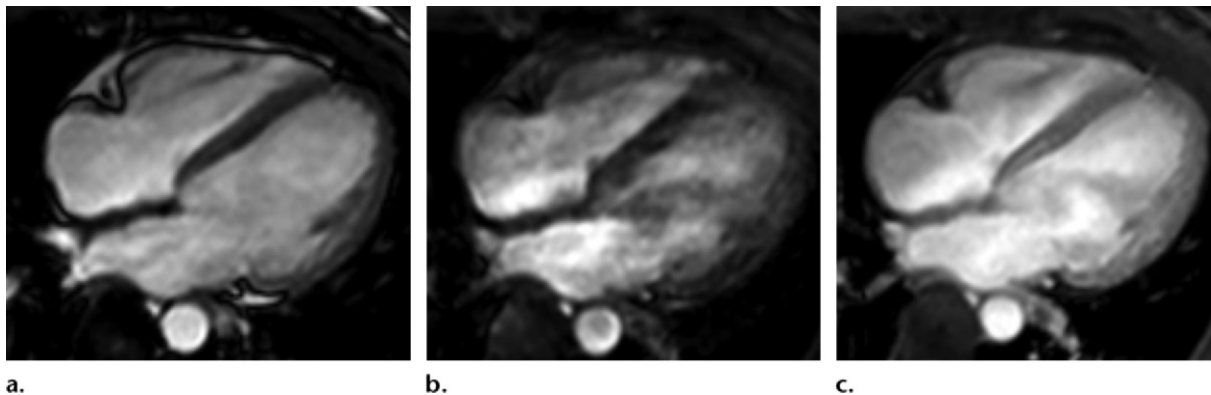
Comparison of SSFP MR image with GRE images obtained before and after contrast agent administration. (a) Four-chamber SSFP MR image shows acceptable SNR and CNR, but artifacts are seen in the left atrial region. (b) Nonenhanced GRE MR image obtained at the same level shows lower signal intensity than on the SSFP image (due to inflow effects) but decreased artifacts. (c) Contrast-enhanced GRE image obtained at the same level as Movies 1 and 2 shows much higher signal intensity of the blood pool, resulting in higher CNR and SNR than seen on the SSFP image. This technique is an alternative to SSFP when there are extensive band or flow artifacts.
